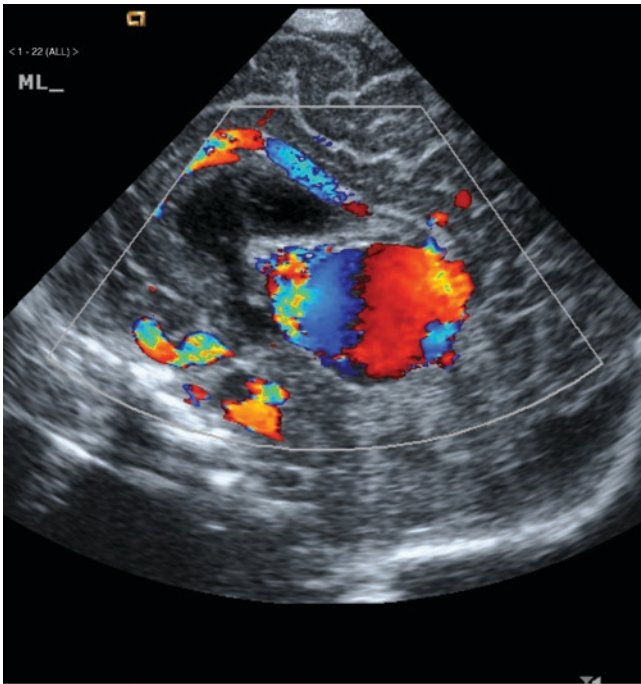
Vein of Galen aneurysmal malformation (VGAM). Midline sagittal cranial ultrasound image with colour Doppler shows turbulent blood flow in a VGAM posterior to the third ventricle
